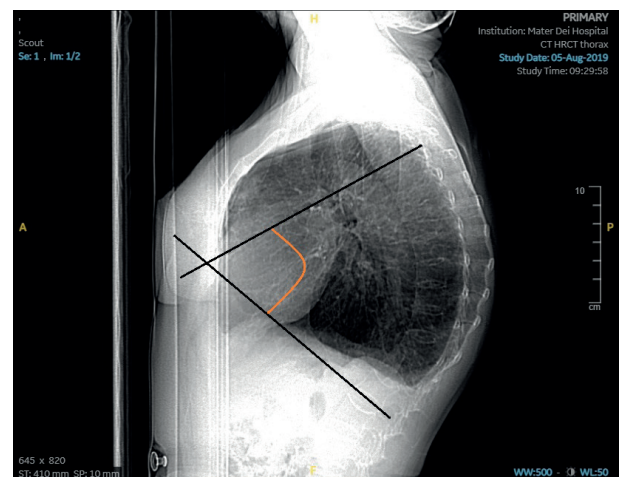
Lateral Chest x-ray showing thoracic kyphosis with a Cobb angle of 73 degrees.
